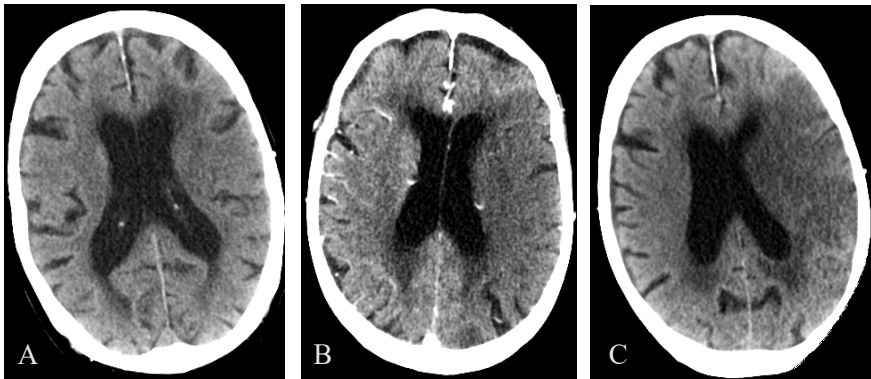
Patient with acute ischemic stroke – left MCA occlusion. A: NCCT. B: “Poor man’s perfusion CT” created from the CTA. C: Postprocedural CT at 24 hours.
